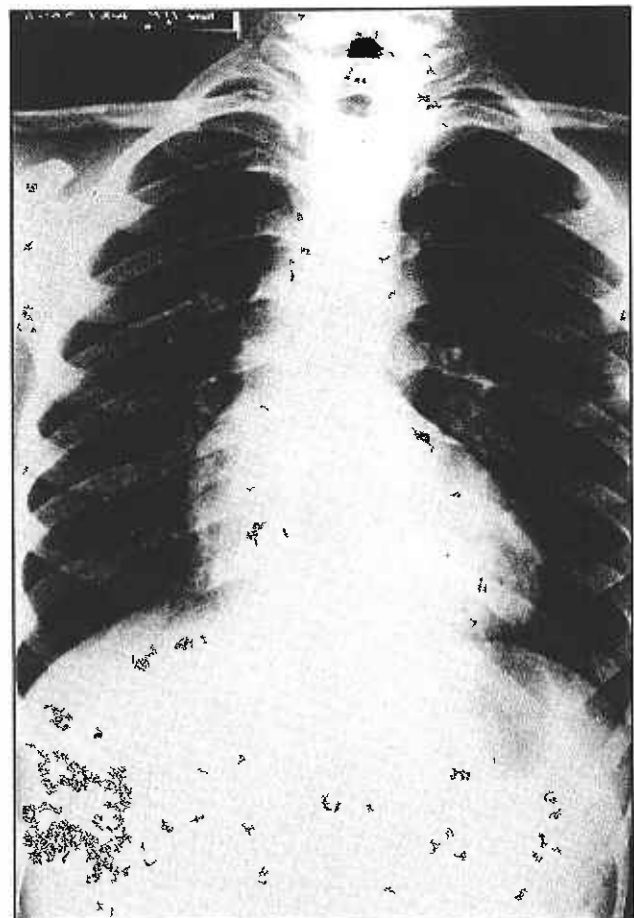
Chest roentgenogram showing typical boot-shaped heart of tetralogy of Fallot with oligemic lung fields and concave pulmonary segment.
